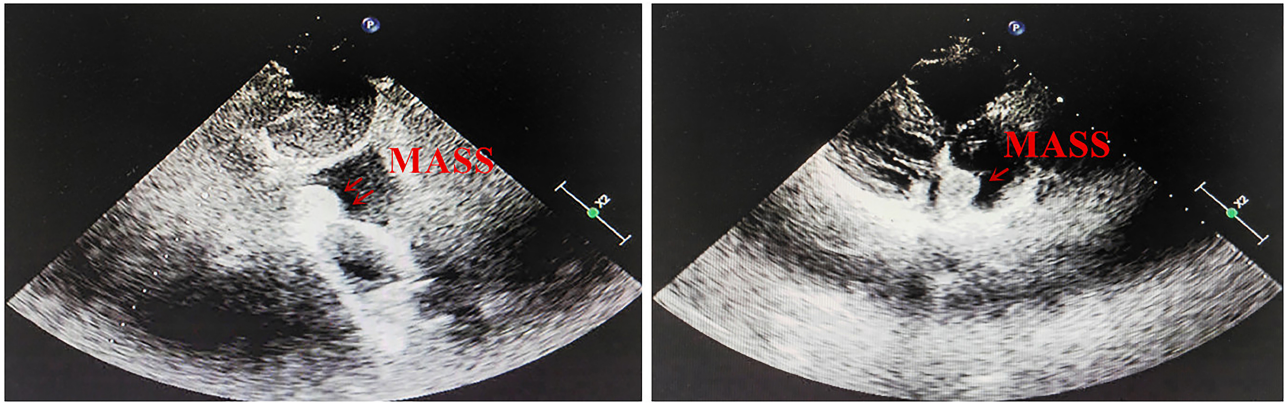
Transthoracic Doppler ultrasound shows a mass in the interatrial septum, near the inferior vena cava. MASS means an abnormal mass, which is the cardiac hemangioma in this case.
